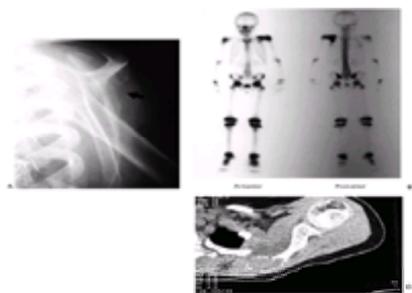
A: This plain radiograph is an oblique view of an 8-year-old girl's scapula. The arrow points to a subtle area of cortical erosion. The patient complained of pain, and there was a tender mass over the scapula. B: On the anterior view of the same patient's technetium 99 bone scan, the increased uptake in the scapula is easily seen. This patient has a solitary Langerhans cell histiocytosis (eosinophilic granuloma), but her lesion is associated with increased uptake. This is true in the majority of cases. C: On the computed tomography scan, a lesion is seen in the medial border of the scapula. After biopsy, curettage without graft was curative.
